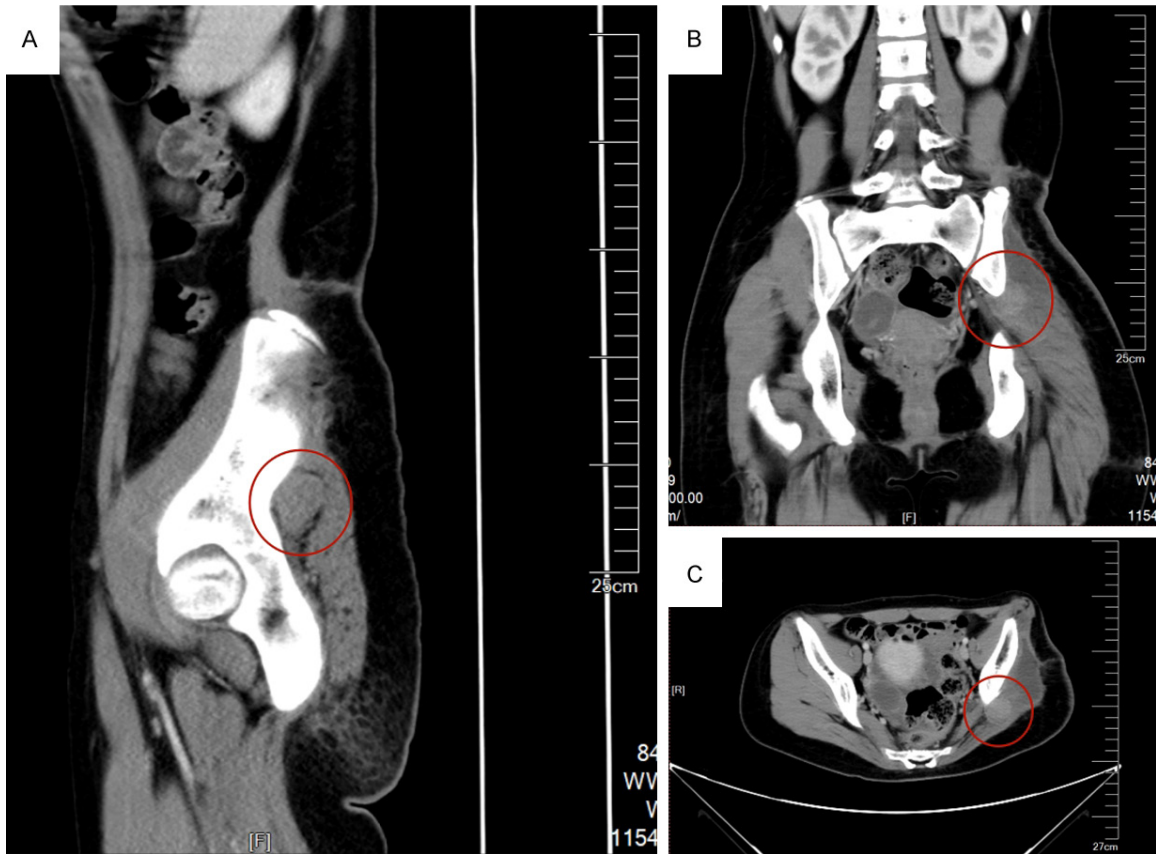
Pelvic CT scans taken one month after the surgery, presented in (A) sagittal, (B) coronal, and (C) transverse views, revealed a nodular lesion near the left piriformis muscle, noted with a red cycle, measuring 1.9×2.7 cm, indicating a local tumor recurrence.
